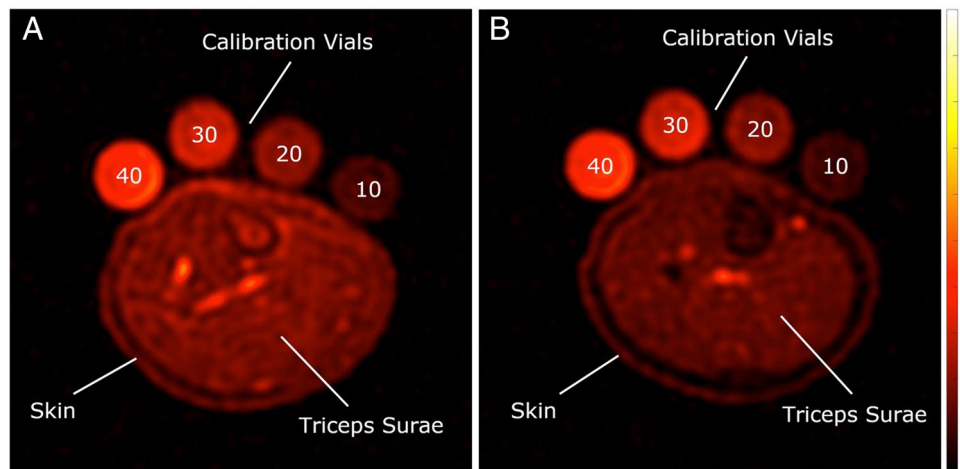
^{23}Na MRI of the leg in a 13-year-old healthy female (A) and a 13-year-old female patient with Fanconi syndrome on indomethacin (B). Images show a substantially reduced skin $[\text{Na}^+]$ ((A) 15.2 mmol/L vs (B) 10.7 mmol/L) and triceps surae muscle $[\text{Na}^+]$ ((A) 18.6 mmol/L vs (B) 14.6 mmol/L) in our case in point, despite
